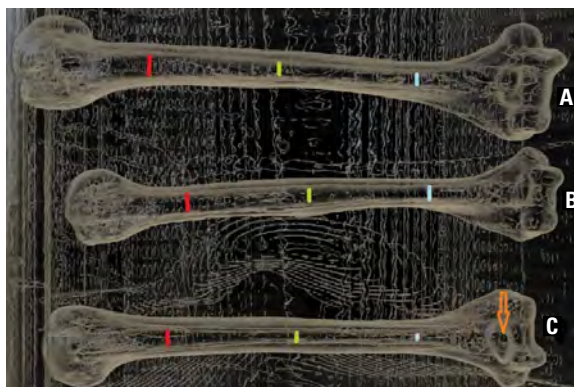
Transparentised image of the three-dimensional reconstructed humeri with computed tomography; A. Control humerus; B. Supracondylar process; C. Supratrochlear foramen (red line: proximal medullary canal width, green line: midshaft medullary canal width, blue line: distal medullary canal width, orange arrow head: supratrochlear foramen).
